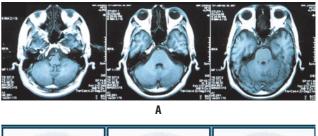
A: Orbital computed tomography proved an increased soft tissue density superior to the left bulbus oculi (white arrows) without an extraocular lesion. B: A sequential ⁶⁷Ga-C images was obtained at 4h, 24h, and 48 h after administration of 370 MBq tracer intravenously. The anterior cranium planar images showed accumulation of the tracer in the left orbital region (black arrows).
